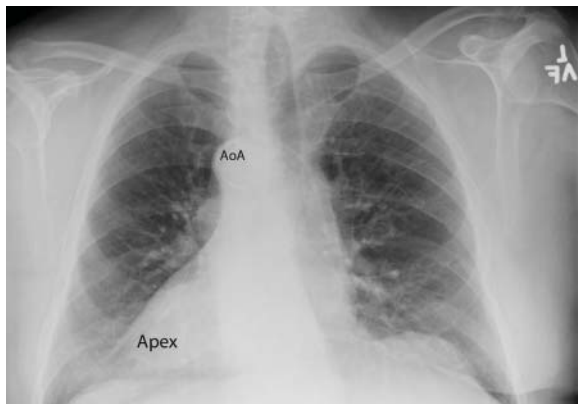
Chest radiography confirmed dextrocardia, showing a right-sided cardiac apex and a right-sided aortic arch (AoA).
